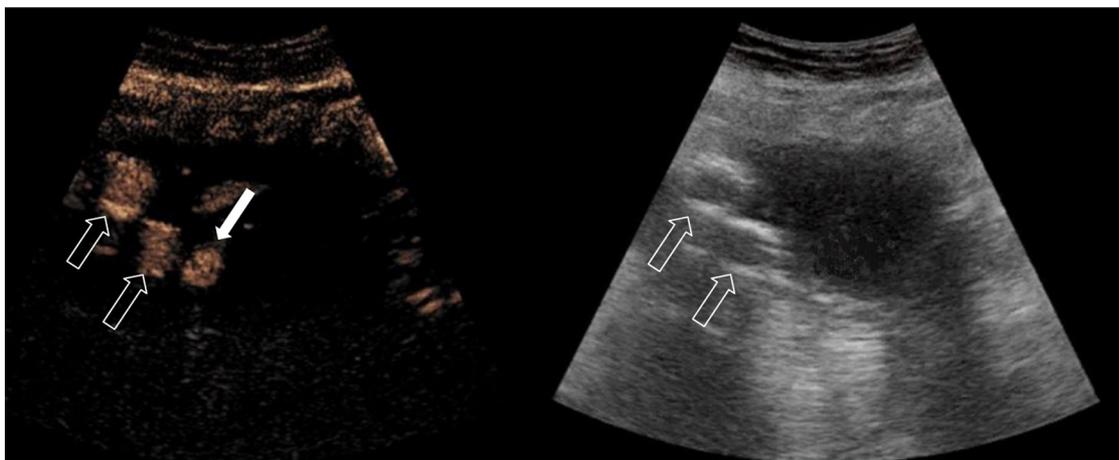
Contrast enhanced ultrasound after endovascular aortic aneurysm repair. Endoleak after endovascular aortic aneurysm repair only seen with contrast enhanced ultrasound (solid white arrow) on the left image. The iliac components (white arrow outline) are contrast filled as well. Courtesy of Kim Bredahl.
